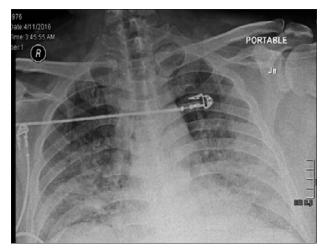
Chest X-ray (portable film) showing bilateral airspace disease, especially at lower lobes more predominant at right lower lobe with septal thickening
